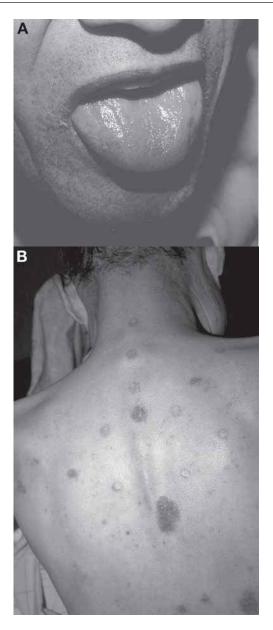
Amyloidosis: 60-yr-old man with (A) large tongue and (B) brown maculopapular lesions on the back. He was admitted in heart failure because of a restrictive cardiomyopathy. Echocardiography showed biventricular hypertrophy and a sparkling appearance to the myocardium. He had biopsy-proven amyloidosis.
